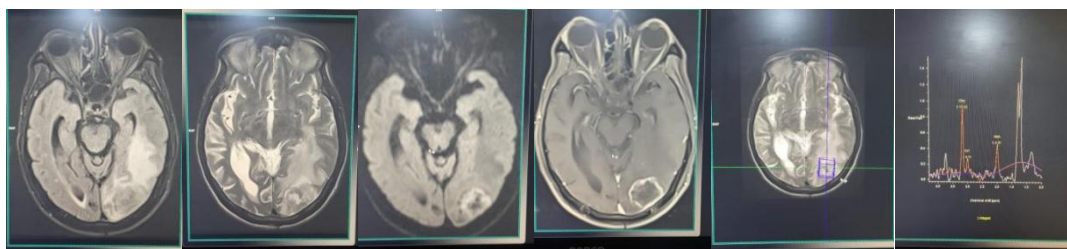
Tuberculoma: T2, FLAIR hyperintense lesion with hypointense rim with restriction on DWI with lipid and lactate peak on MRS in left occipital lobe
